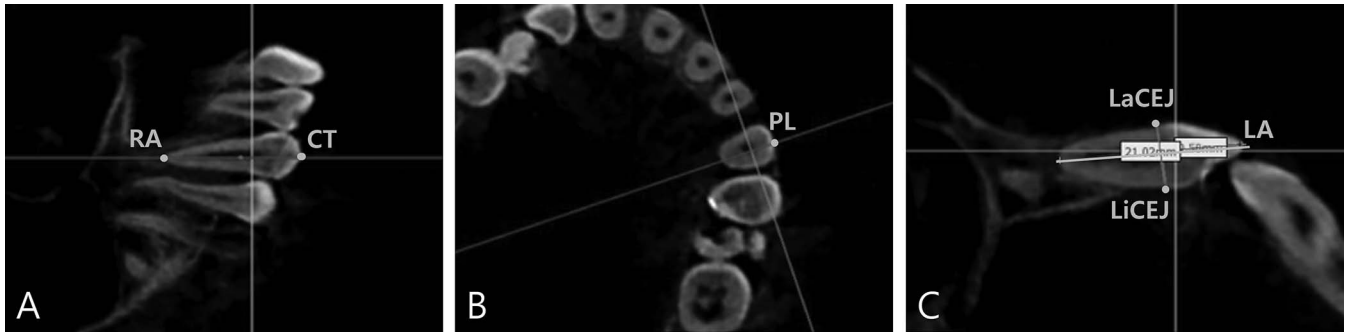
Reference points and lines used to measure the variables: (A) View that includes both AT and CT; (B) Axial view at CEJ level; (C) View from the plane defined by AT, CT, and PL. RA, root apex; CT indicates cusp tip; PL, most prominent point of the labial surface; LA, long axis (orange line); LaCEJ, labial CEJ; LiCEJ, lingual CEJ.
